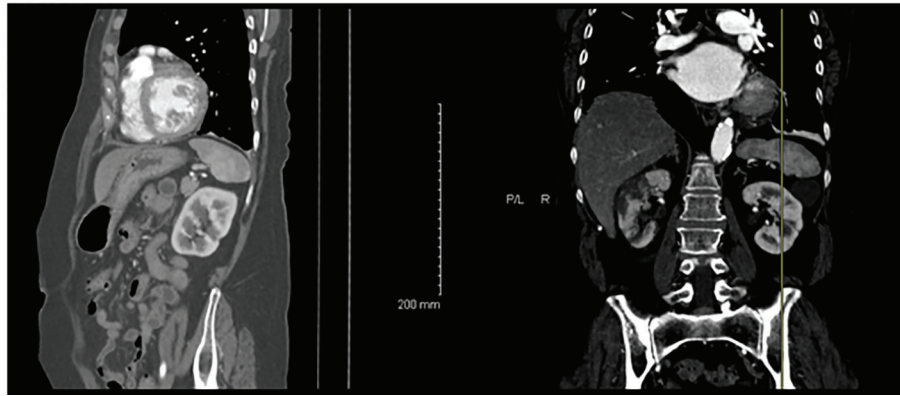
CT scan of the abdomen showing bilateral kidney infarctions.
